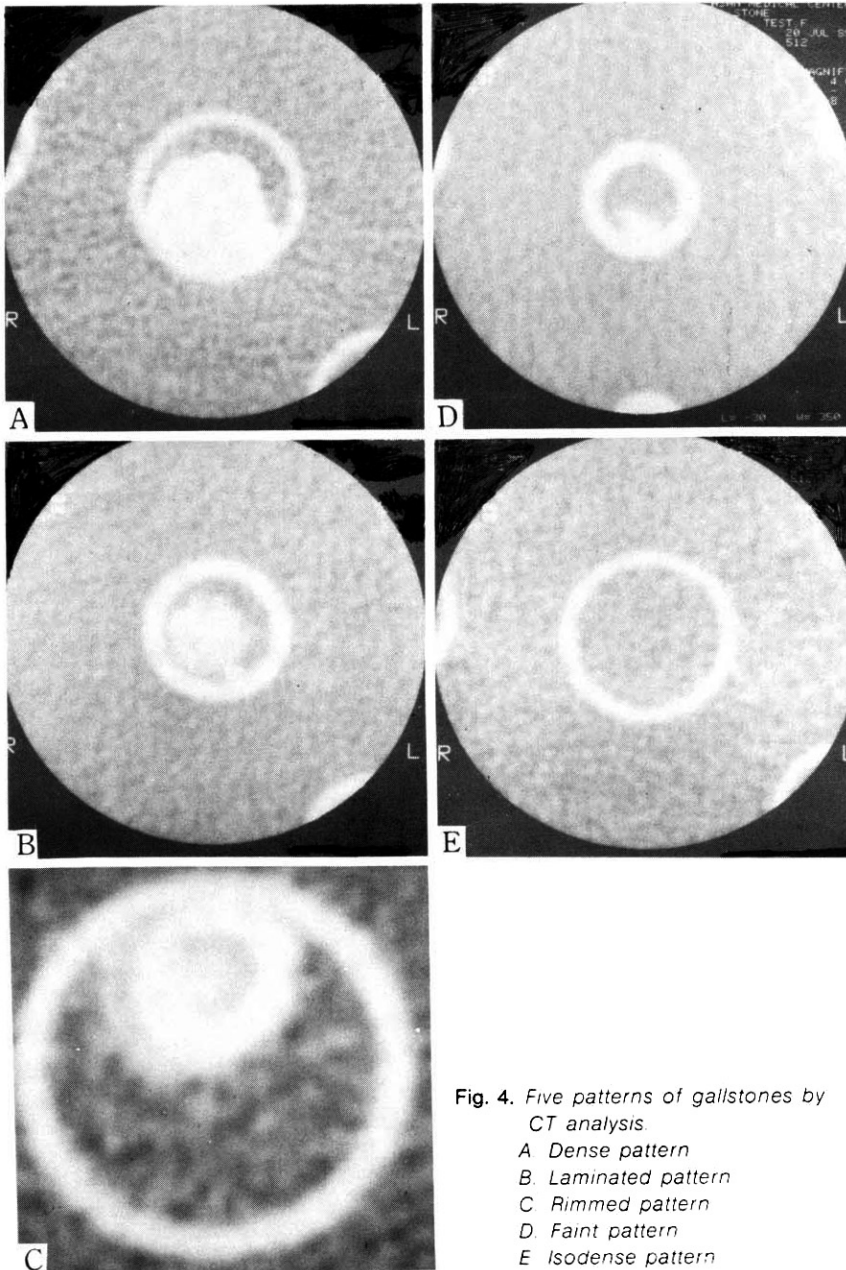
Five patterns of gallstones by CT analysis
